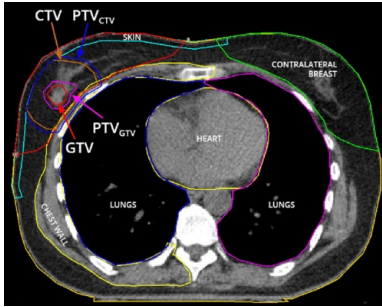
Example of a CT scan on which the contours of the organs and the tumour have been drawn.[8]
